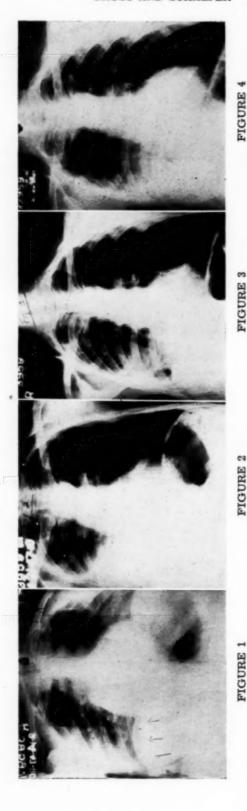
Roentgenogram of the chest showing air under the right leaf of the diaphragm and demonstrating smooth diaphragmatic contour (2-14-47).—Figure 2: Pleuro-diaphragmatic effusion obscuring underlying parenchymal detail (4-21-47).—Figure 3: Multi-locular fluid levels at the right base with irregular parenchymal infiltration.— Figure 4: Dense pleural thickening at the right base, obscuring parenchymal detail.
